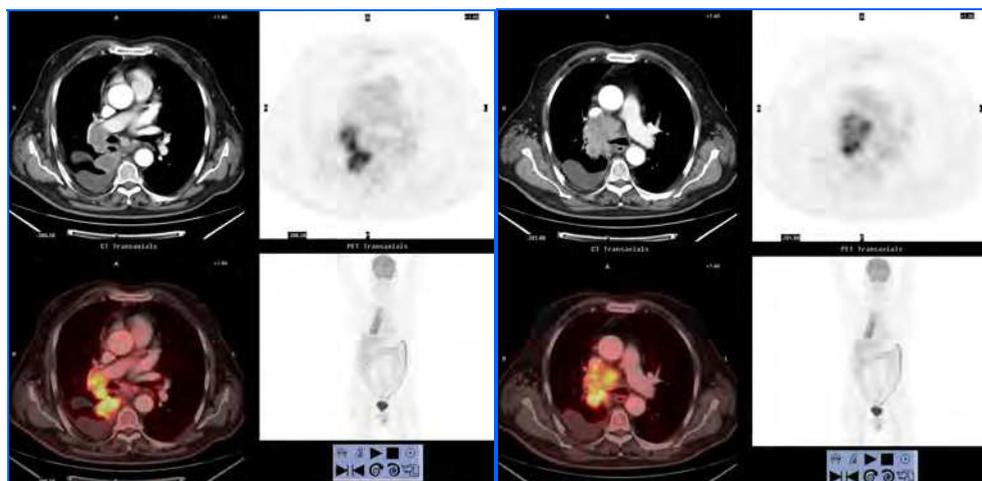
PET/CT: Staging of NSCLC with mediastinal adenopathies, with an important 18FDG uptake. The invasion of the right main pulmonary artery can be seen thanks to the intravenous contrast. The pleural effusion does not show an 18FDG uptake.
